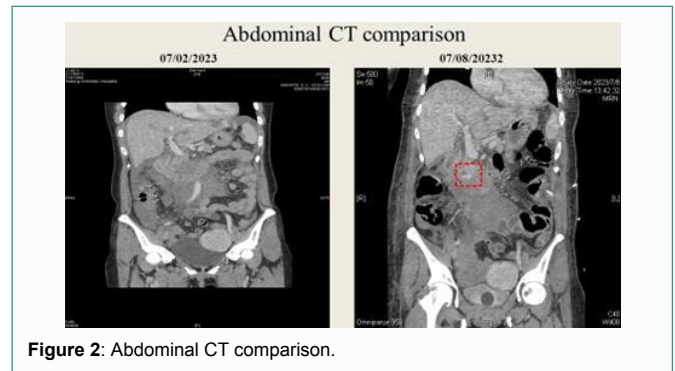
Abdominal CT comparison.
